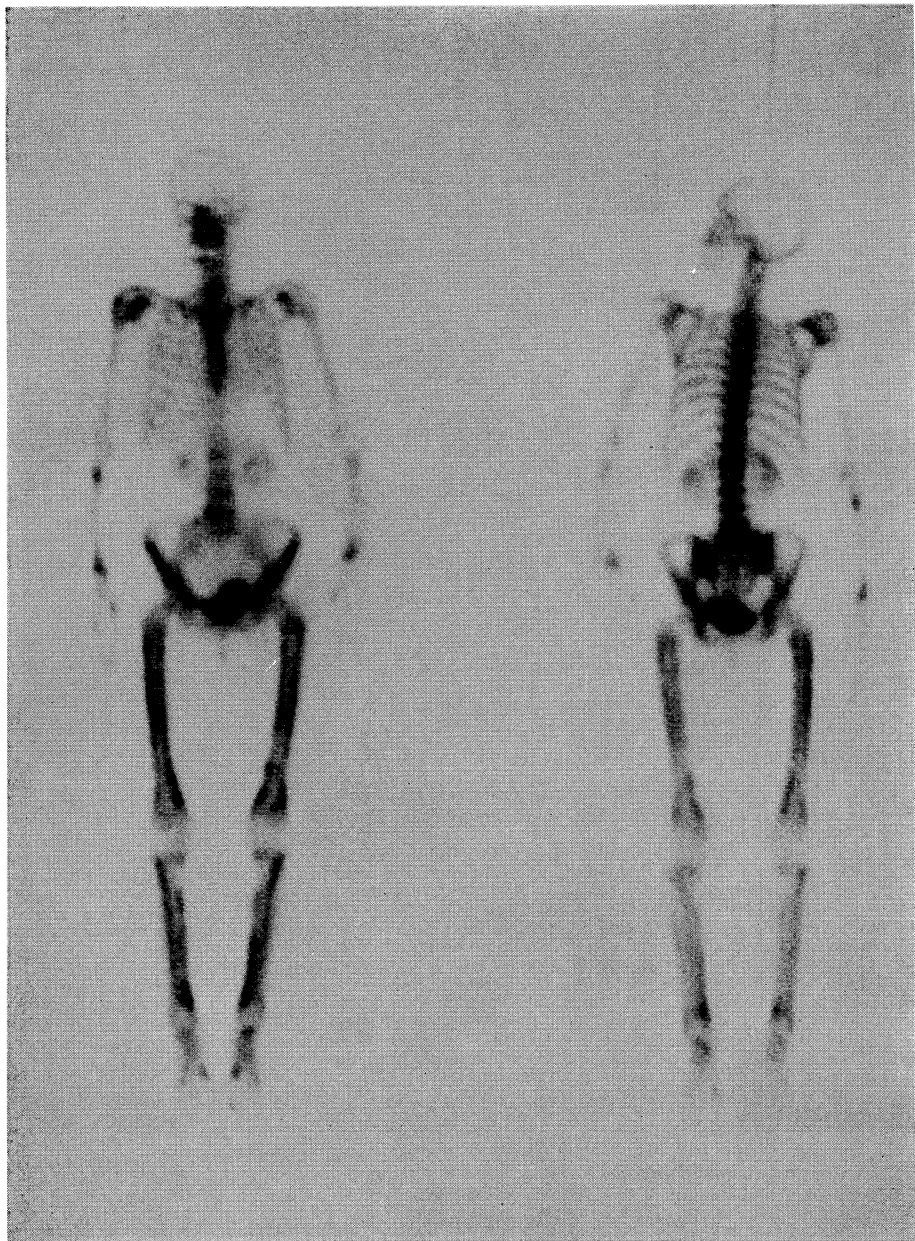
Bone scintigraphy showed increased pericortical concentration along the femoral, tibial, and fibular shafts.
